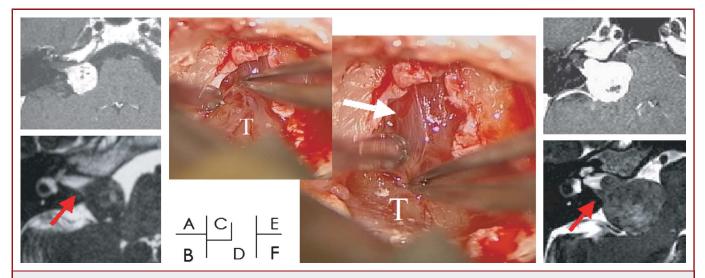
Preoperative magnetic resonance and intraoperative images of 2 patients whose acoustic neuromas were classified as epiarachnoid tumors (a 55-year-old man [A-D] and a 38-year-old women [E, F]). Preoperative magnetic resonance imaging scans (A, B, E, F) showed similar findings: the tumor did not extend to the fundus acousticus, and the tumor was distributed along the posterior wall of the internal auditory canal (IAC) (red arrows). After dissection of the tumor (T) in the IAC via the lateral suboccipital approach, we found an intact arachnoid membrane (white arrow) behind the tumor, covering the nerves running through the meatus (C, D).
